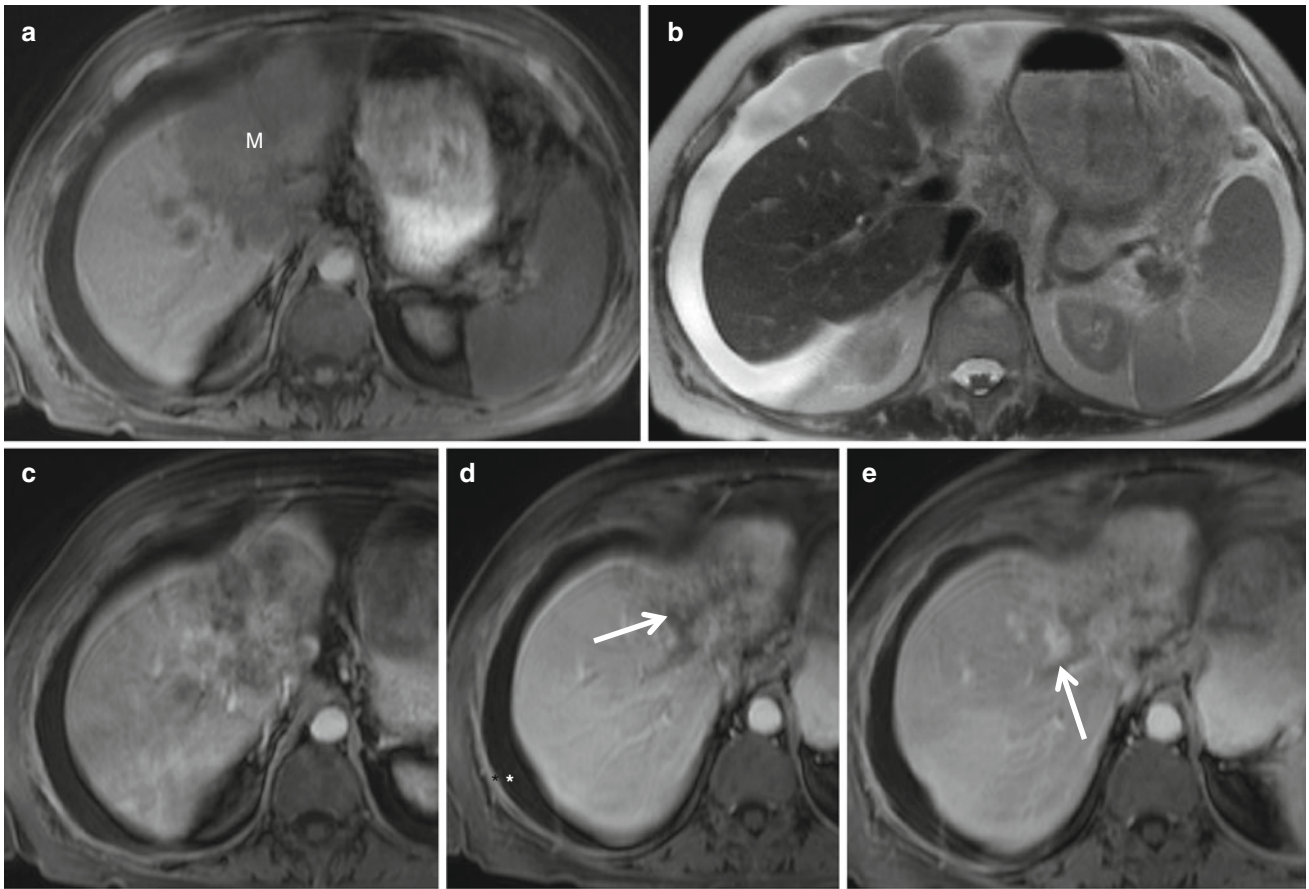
Shrinkage of left hepatic lobe is noticed. a T1-weighted image shows a hypointense mass (*M*), which nearly replaces the entire left lobe of the liver, and it measures 8 × 7 cm. There is mild intrahepatic biliary duct dilatation (arrows). After contrast administration (c–e), there is late and heterogeneously enhancement of the mass. There is ascites seen in abdomen (*)
